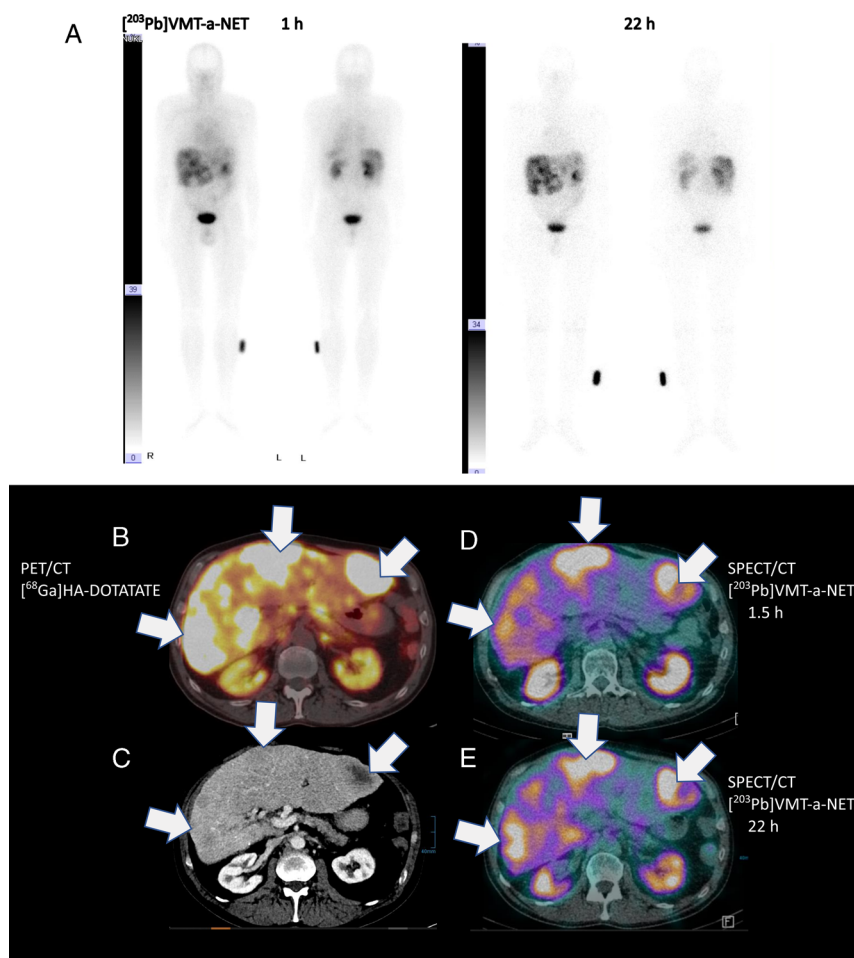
Tyr3-octreotide (TOC) variant VMT- α -NET is a novel and ideal ligand for $^{203}\text{Pb}/^{212}\text{Pb}$ that shows lower renal excretion, higher neuroendocrine tumor uptake, and high chelation properties for retention of daughter α -particle emitting radionuclide ^{212}Bi . In an end-stage midgut neuroendocrine tumor patient with carcinoid heart disease, right ventricular dysfunction, mildly reduced renal function, and refractory to 6 cycles of ^{177}Lu -HA-DOTATATE therapy, planar, and 22 hours ^{203}Pb -VMT- α -NET SPECT/CT (low dose) images were acquired after injection of 224 MBq of ^{203}Pb -VMT- α -NET to assess the feasibility of performing ^{212}Pb -VMT- α -NET therapy. The patient tolerated the injection without any significant alteration in the vital parameters. There was rapid renal clearance of the tracer within the first hour itself as was evident from tracer excretion in the urinary bladder and in the renal pelvicalyceal system. Because of known right ventricular dysfunction, there was evidence of blood pool activity in the heart, which however decreased significantly after 21 hours. A comparison of the 1.5 and 22 hours SPECT/CT images with ^{68}Ga -HA-DOTATATE PET/CT images (contrast-enhanced diagnostic CT) showed high uptake of ^{203}Pb -VMT- α -NET in liver metastases matching with the results of the PET/CT. A, Anterior and posterior planar images acquired at 1 and 22 hours. B, Fused ^{68}Ga -HA-DOTATATE PET/CT transverse slice. C, Transverse contrast-enhanced CT image. D and E, SPECT/CT (low-dose) fused transverse slice. Arrows are showing the liver metastases.¹⁻⁸
